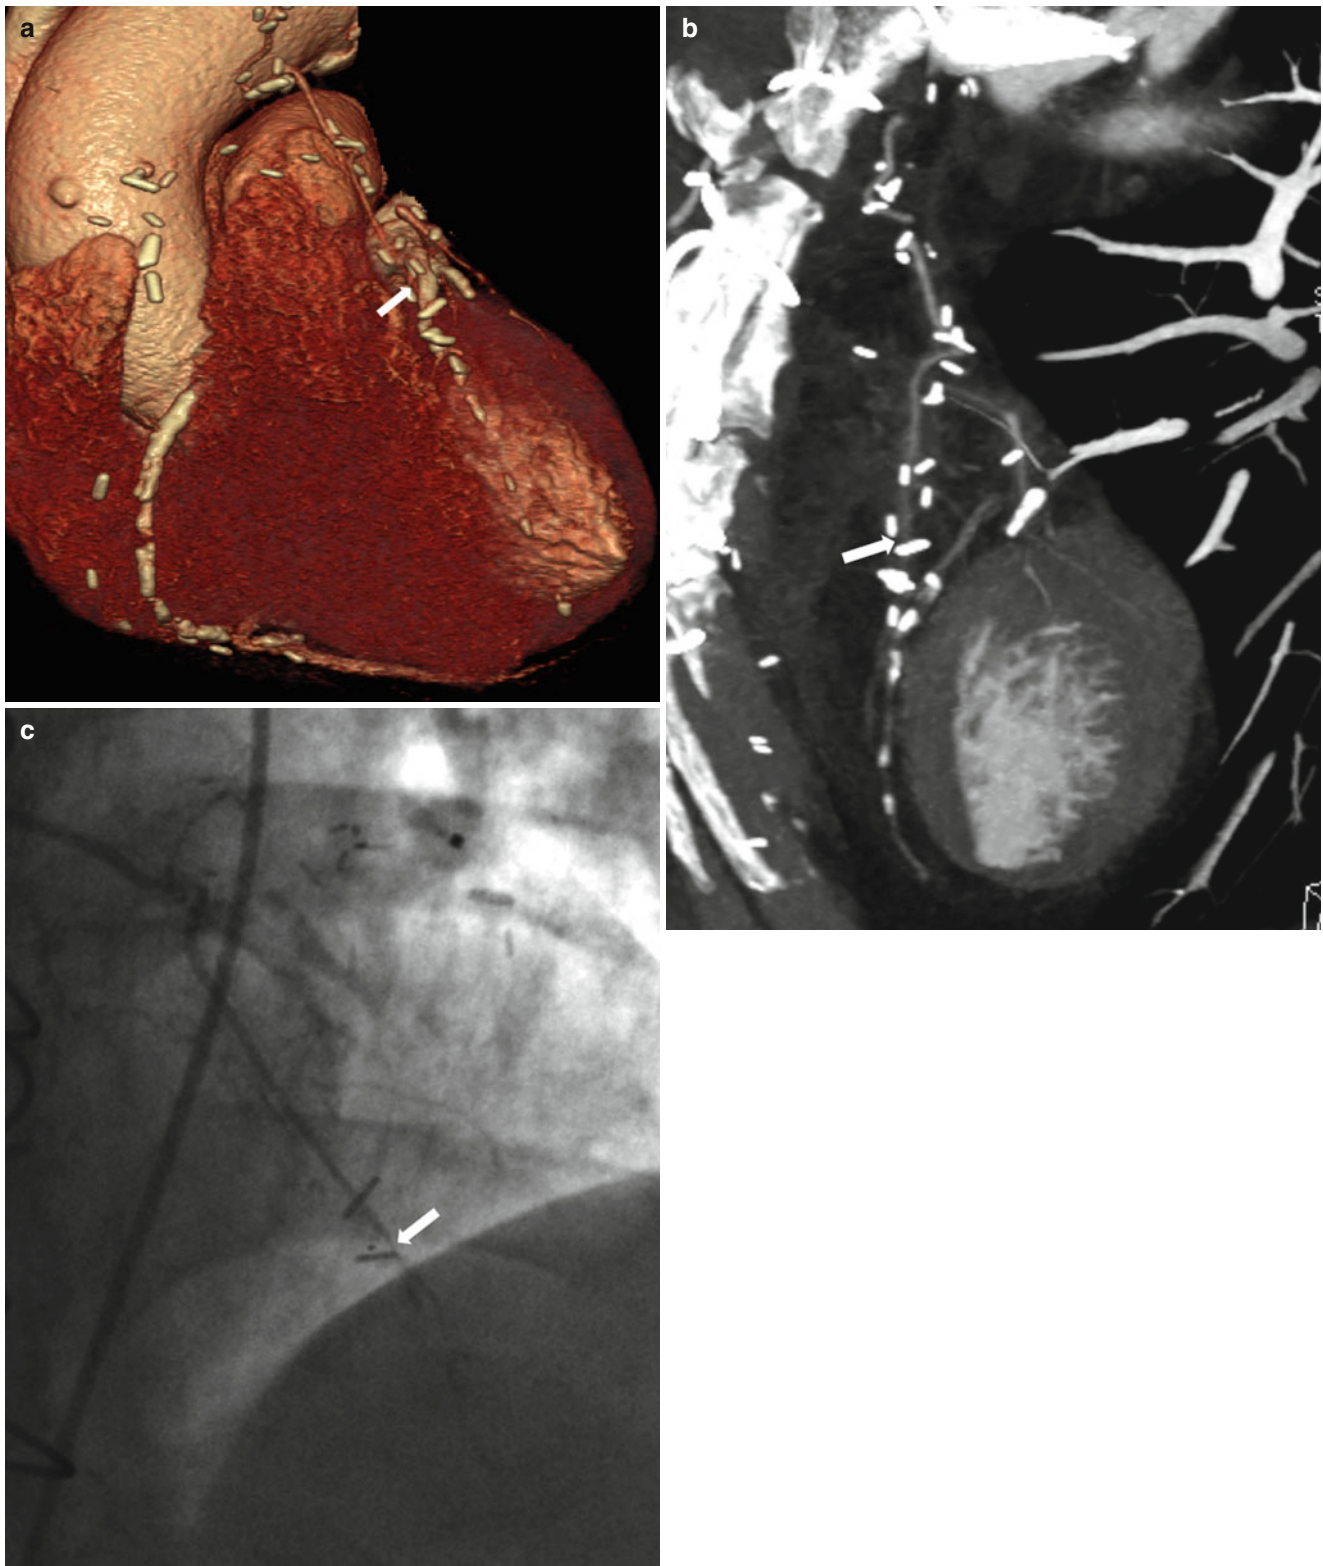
Severe stenosis in LIMA graft. (a) Volume rendering and (b) maximal intensity projection CT images demonstrated severe stenosis (arrows) in the distal portion of the LIMA graft and anastomosis site.
